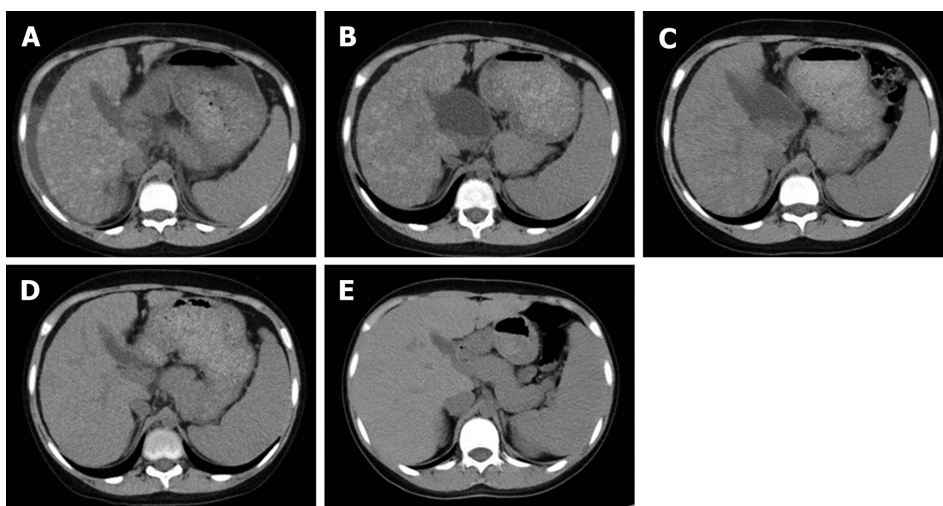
Hepatic computed tomography image obtained while receiving Zn and trientine treatment. The mottled nodular shadows with a high density in the liver improved over time. However, splenomegaly did not improve. A: On admission; B: 1 mo after treatment; C: 2 mo after treatment; D: 4 mo after treatment; E: 14 mo after treatment.
